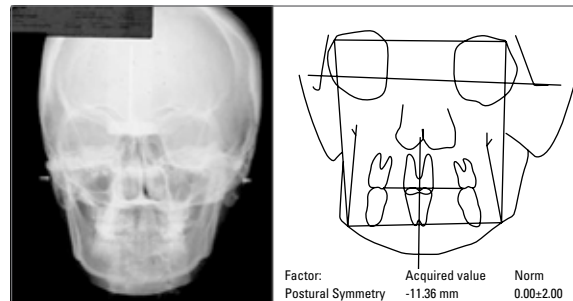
Woman's posteroanterior radiograph and cephalometric tracing.
